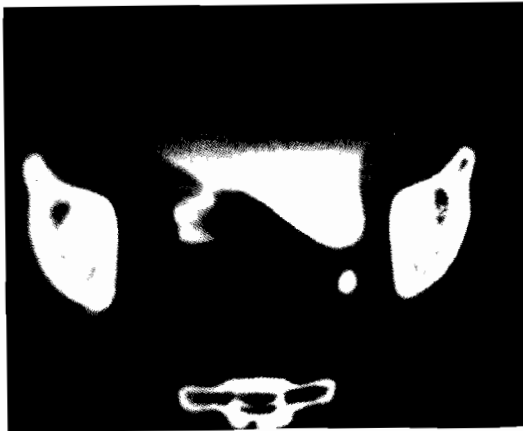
CT scan showing a fistulous communication between the retrovesical hydatid cyst and the urinary bladder. The rectum is pushed aside and the lumen is obscured.
